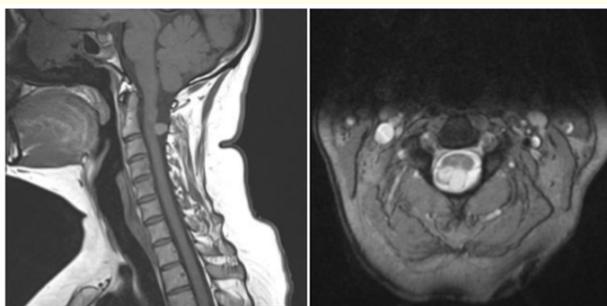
Sagittal and axial magnetic resonance imaging image showing cystic lesion, behind C2 posterior to the cord. Lesion is hypointense on T1-weighted images and hyperintense on T2-weighted images.
